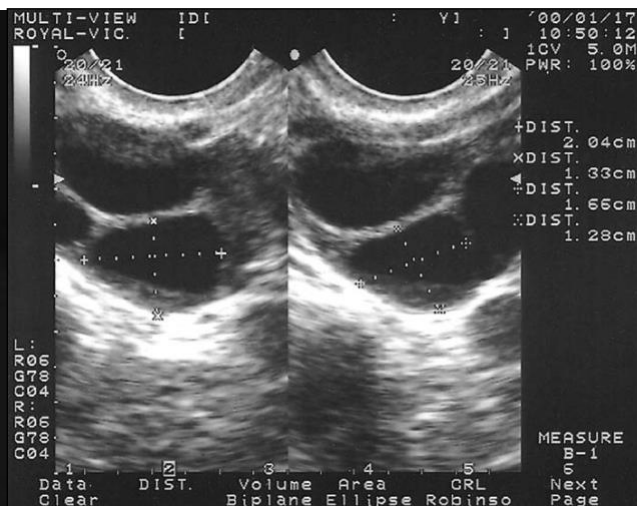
Transvaginal ultrasound scan of polycystic ovary after treatment.
